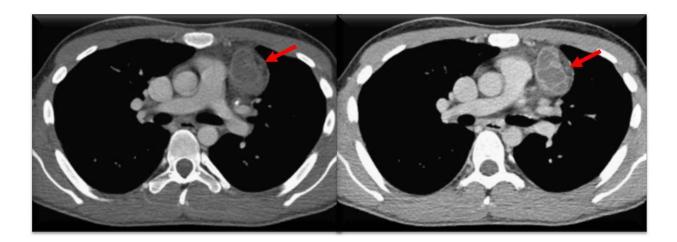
Mature cystic teratoma. A contrast-enhanced CT scan shows a multilocular cystic mass in the left anterior mediastinum, with areas of fat attenuation (arrows).
